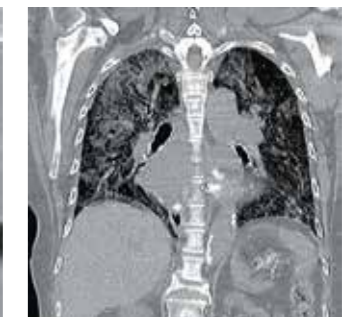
High-resolution computed tomography chest coronal view showing moderate reticular opacities seen in bilateral lung parenchyma with mild interlobular and intralobular septal thickening and mild traction bronchiectasis within and associated with moderate ground-glass opacities
